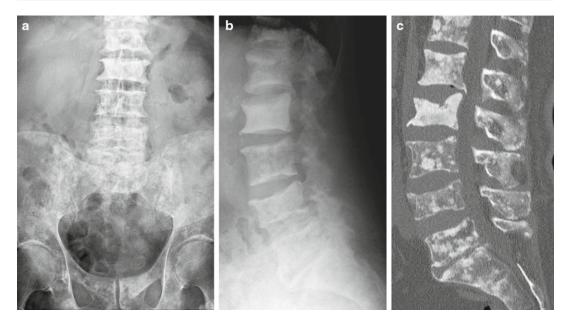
Metastatic prostate cancer affecting the lumbar spine. Frontal (a) and lateral (b) radiographs in a man with low back pain reveal extensive blastic (bone-forming)
